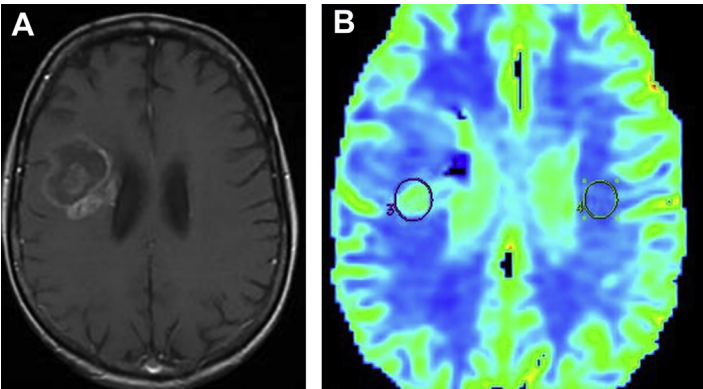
A 65-year-old male patient with previously treated right frontal glioblastoma presented with new cognitive symptoms. T1 postcontrast MR imaging showed a new ring-enhancing lesion in the right frontal deep white matter (A) that could represent either radiation necrosis or recurrent tumor. (B) Corresponding perfusion map shows increased rCBV within the posterior enhancing wall, suspicious for tumor. Biopsy revealed tumor recurrence.
